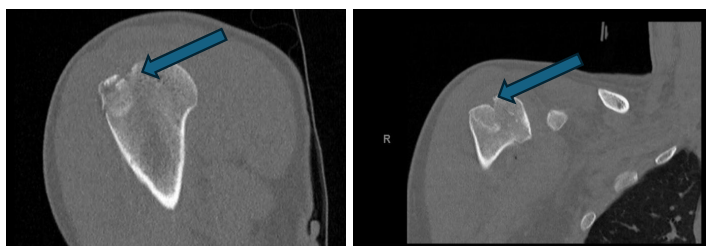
Right shoulder computed tomography showing comminuted greater tuberosity fracture.
